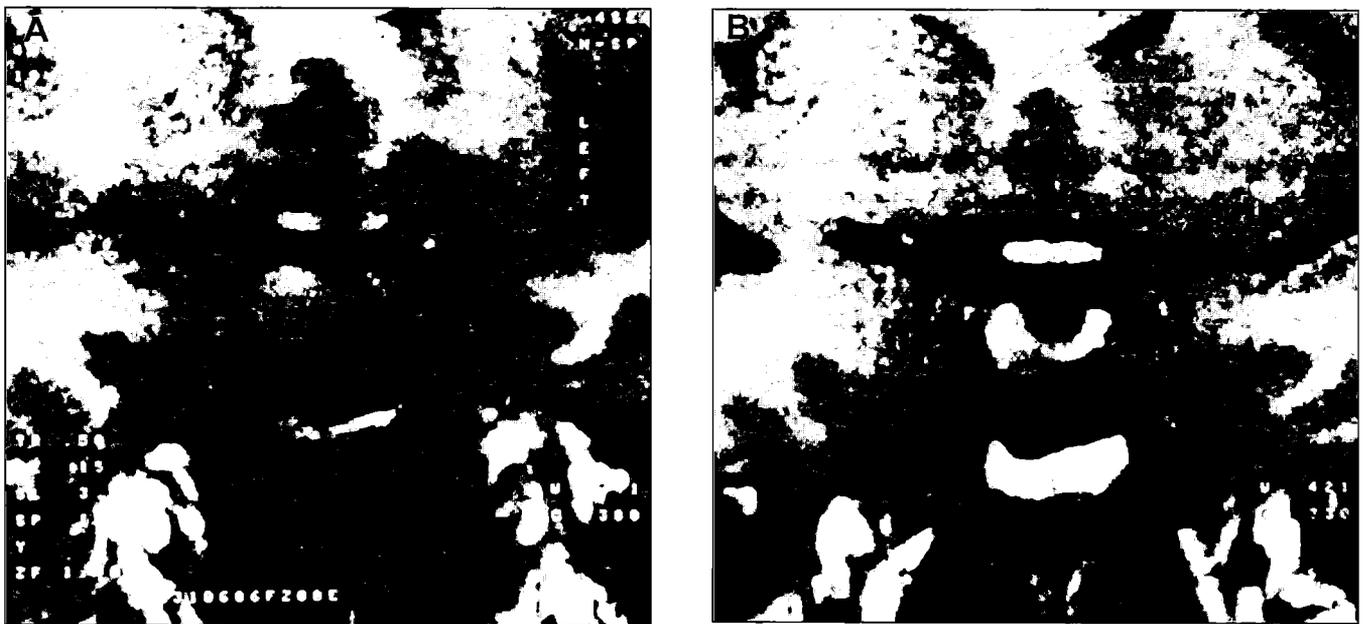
Magnetic resonance images (MRI) of a pituitary macroadenoma one month before (above) and four months after (below) initiation of octreotide therapy. (Adapted from Stevenaert A, Harris AG, Kovacs K, Beckers A⁶⁴).
